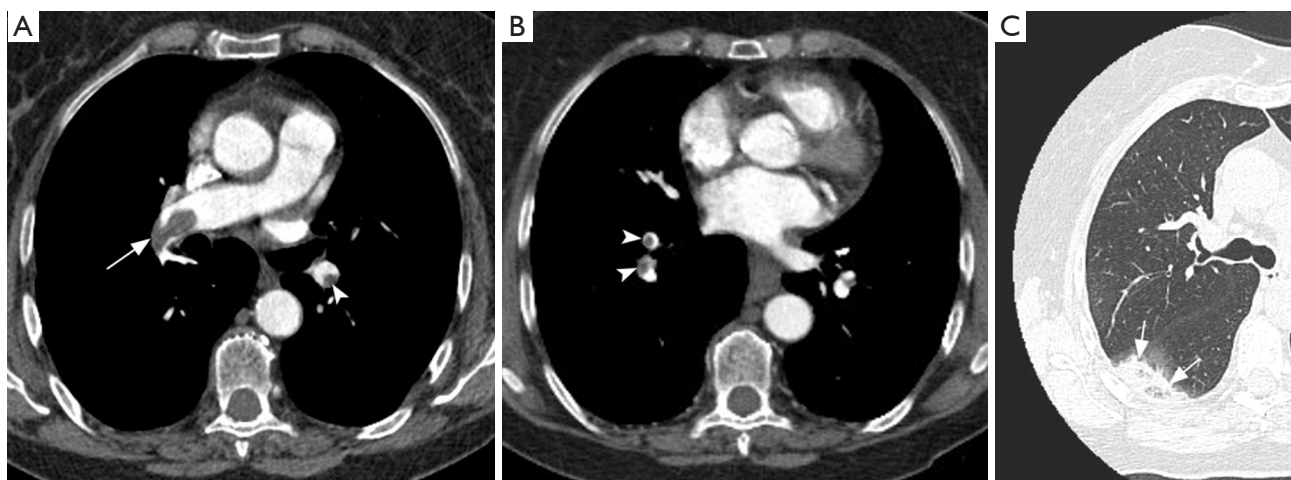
CT pulmonary angiography (CTPA) images in acute pulmonary embolism. Axial CTPA images (A and B) show partial filling defects, centrally located in the right pulmonary artery (arrow) and eccentric in segmental branches (arrowheads). Note acute angle between thrombi and vessel walls. Axial lung window (C) shows “reversed halo sign” in the right lower lobe (arrows), a nonspecific sign of pulmonary infarction.
